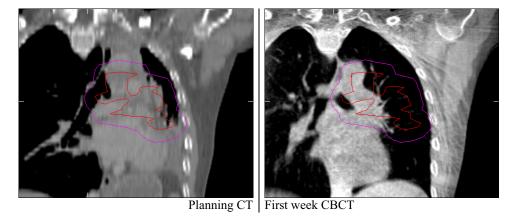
Example of progressive anatomical changes requiring plan adaptation depicting the planning CT (left) and first week CBCT (right) aligned on the bony anatomy. Pretreatment GTV (red) and PTV (purple) delineations are overlaid on both scans. Due to shrinkage of the tumor the atelectasis (seen on the planning CT scan) dissolved and a shift of mediastinal structures to the normal position occurred (seen on the CBCT scan). As a consequence, the dose distribution changed, the dense tissue of the collapsed lung dissolved, the tumor, and subcarinal lymph node moved outside the PTV and excessive irradiation of normal lung tissue occurred.
